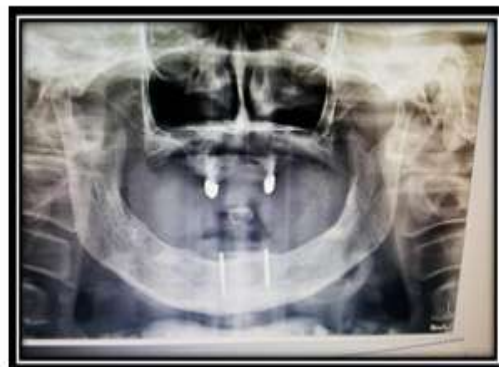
Radiograph showing abutment teeth with metal copings in maxillary arch and two implants in the mandibular arch
